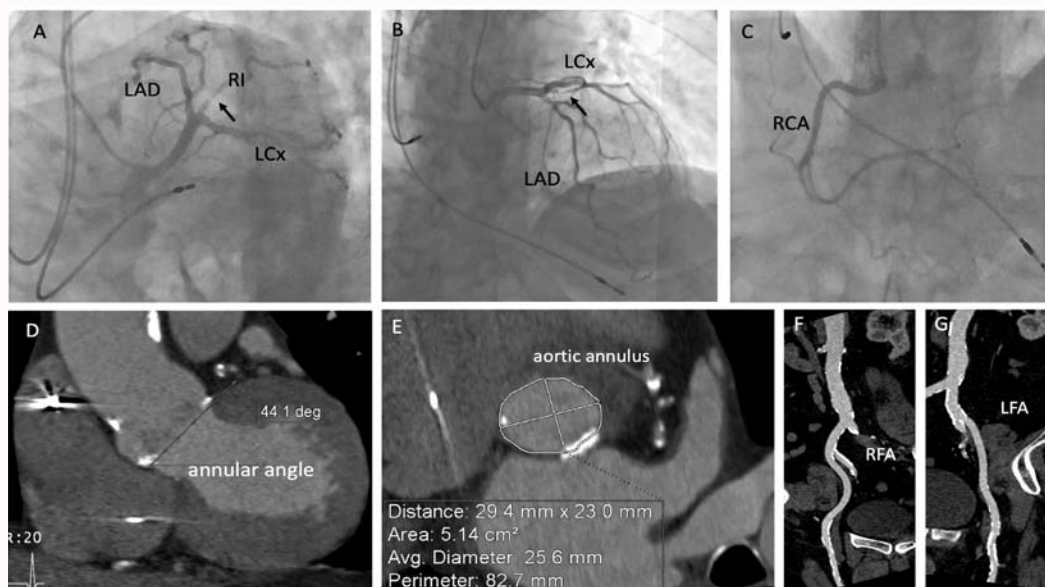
Coronary angiogram (images A-C) and pre-procedural CTA (images D-G). Left coronary artery (images A and B) and right coronary artery (image C) showing an obstructive lesion in the proximal ramus intermedius (arrow). (LAD – Left Descending Artery; LCx – Left Circumflex Artery; RI: Ramus Intermedius; RCA: Right Coronary Artery; RFA: valve Corevalve Evolut PRO 29 mm right femoral artery; LFA – Left Femoral Artery).
